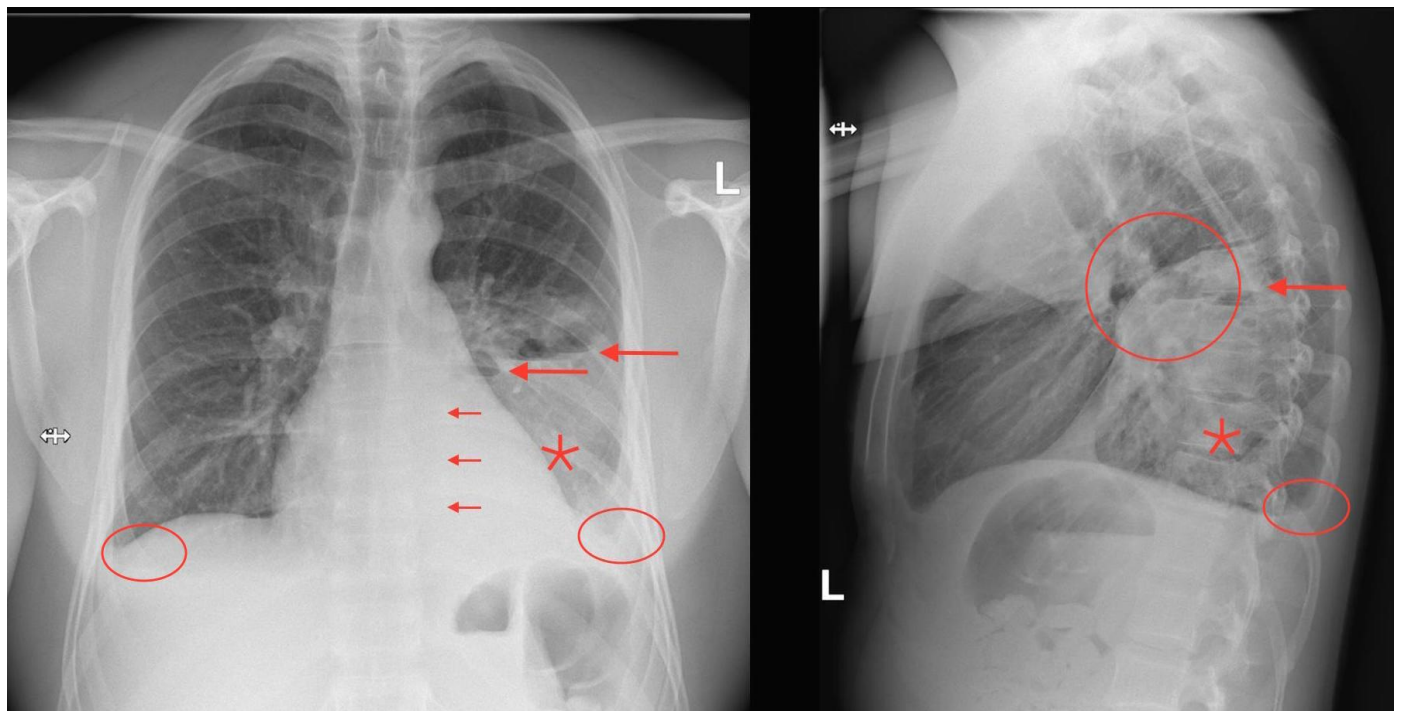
23 year old male with post obstruction pneumonia and pulmonary abscess due to mucoepidermoid carcinoma of the airways. Technique: plain PA and lateral radiograph (Siemens. 0,2 mm CU filter. PA:125 kV; 2,6 mAs. Lateral: 125 kV; 24,2 mAs). Findings: Progression of consolidation in the left lower lobe (red asterisks) en silhouette sign of the descending thoracic aorta (small red arrows). Multiple gas pockets with fluid levels (large red arrows). Bilateral pleural effusion, predominantly on the left (red ovals). Anterior bulging of the major fissure due to mass effect in the left lower lobe (red circle).
